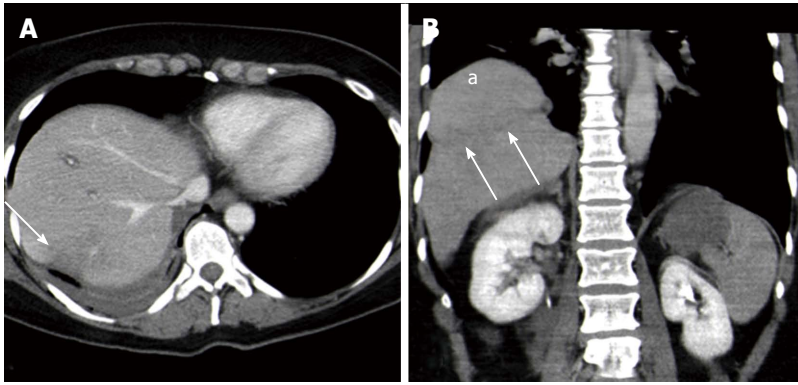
Computed tomography findings in blunt diaphragmatic lesions - hump and band sign. These 3 mm thick multiplanar axial (A) and coronal (B) reconstructions show a hypodense band that crosses the liver parenchyma in the site where it crosses the ruptured diaphragm (arrows), whereas the liver dome expands above it. This alteration represents the so-called "hump and band sign" (a).
